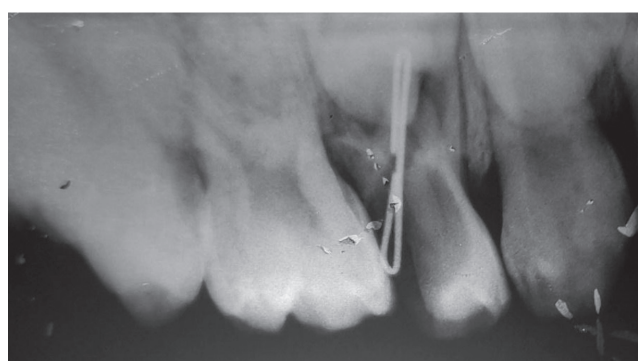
Radiographic examination w.r.t. 64
